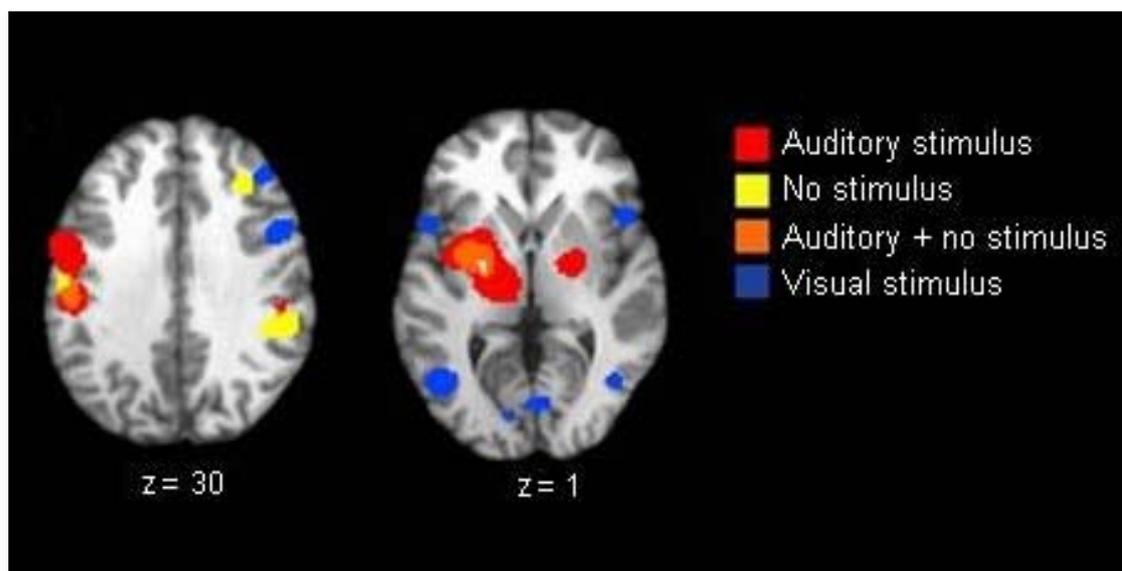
Representative axial slices for simple motor tasks activations when paced by auditory, visual or no stimuli in blood oxygen level dependent signal in functional magnetic resonance imaging studies. Figure was taken from Witt et al. (2008).
